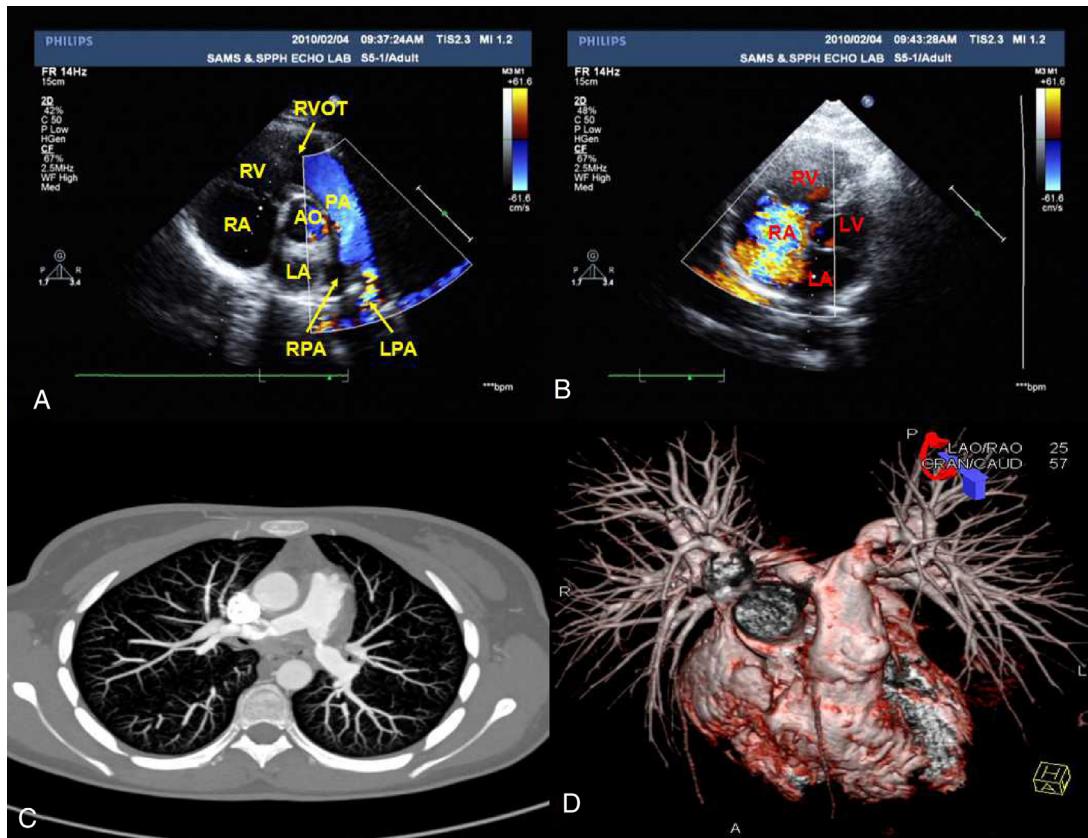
(A-B) Echocardiography 6 months after symptom onset. It showed colorful blood flow in left branch of pulmonary artery due to the stenotic lesion (A) and remarked tricuspid regurgitation (B). (C-D) Dual source computed tomography of pulmonary artery 4 months after symptom onset. It revealed the considerably stenosis of both branches of pulmonary artery (arrows) and no evidence of aorta involvement. LV, left ventricle; LA, left atrium; RV, right ventricle; RA, right atrium; AO, aorta; PA, pulmonary artery; LPA, left branch of pulmonary artery; RPA, right branch of pulmonary artery; RVOT, right ventricular outflow tract.
